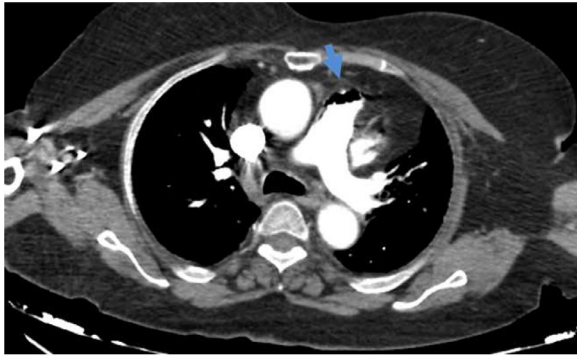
Axial chest computed tomography angiography image at the level of the pulmonary trunk, identifying the air-fluid level in the lumen of the pulmonary trunk (arrow), compatible with gas embolism.
